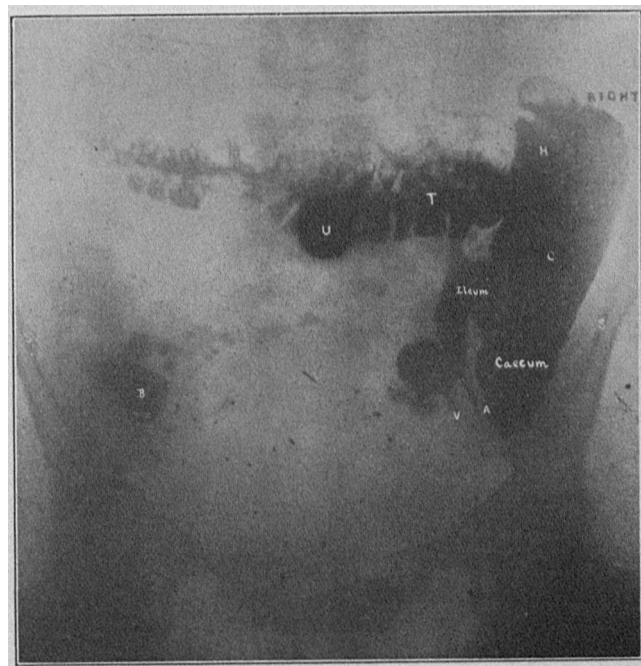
Radiograph taken five hours after the ingestion of a bismuth meal (Case 1). A, base; V, the tip of the vermiform appendix; U, umbilicus; T, transverse colon; H, hepatic flexure; B, remnants of bismuth in coils of small intestine; S. S., anterior superior spines.
